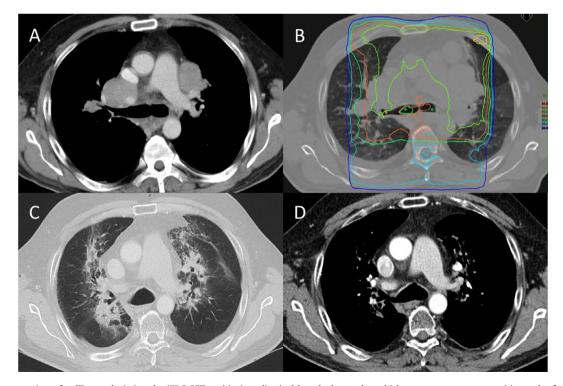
(A) Transverse view of a CT scan depicting the (FDG-PET-positive) mediastinal lymphadenopathy, which was proven tumour positive and referred for palliative irradiation in March 2016. (B) Radiation treatment plan encompassing the affected hilar and mediastinal lymph nodes (30 Gy total dose in 10 fractions of 3 Gy). The coloured lines represent the various isodose lines (see legend). (C) When the patient presented with shortness of breath (NYHA class II, CTCAE grade 2), the CT scan (lung setting) revealed ample radiological changes corresponding with a pneumonitis after irradiation, combined with immunotherapy and underlying HIV-infection as well as sarcoidosis (December 2016). (D) Complete remission of the mediastinal lymphadenopathy was diagnosed in March 2017.
